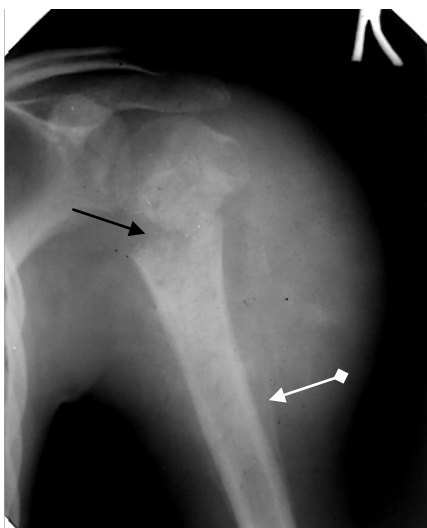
Radiograph of the humeral joint in a direct projection. In area of proximal epiphysis and humeral bone metaphysis there is destruction with pathological fracture and cross-section displacement of fragments (arrow). Codman's triangle (arrow with rhombus). Osteosarcoma of the humeral bone with pathological fracture
